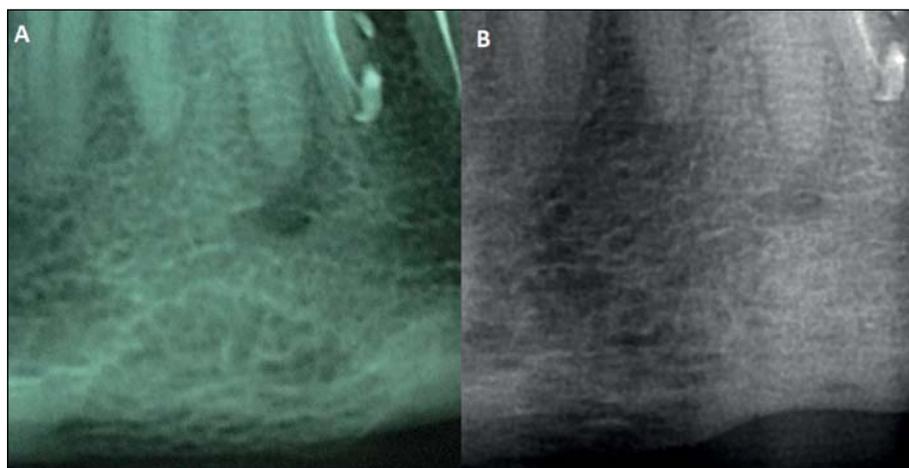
Comparative orthopantomograms one year of evolution.
